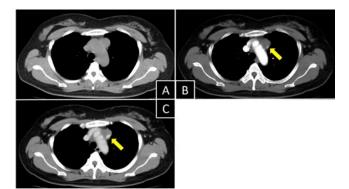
Dynamic computed tomography (CT) of the thorax
